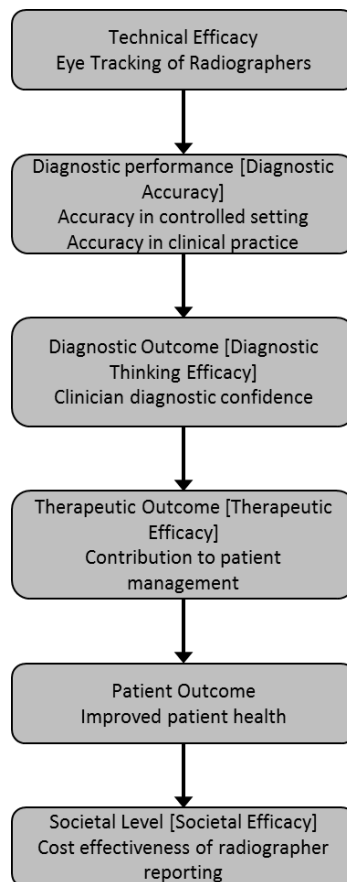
Brealey's hierarchy of efficacy for radiographer reporting with possible outcome measures for each level (adapted from Brealey 2001⁶² and Brealey and Scally 2008⁶³)
